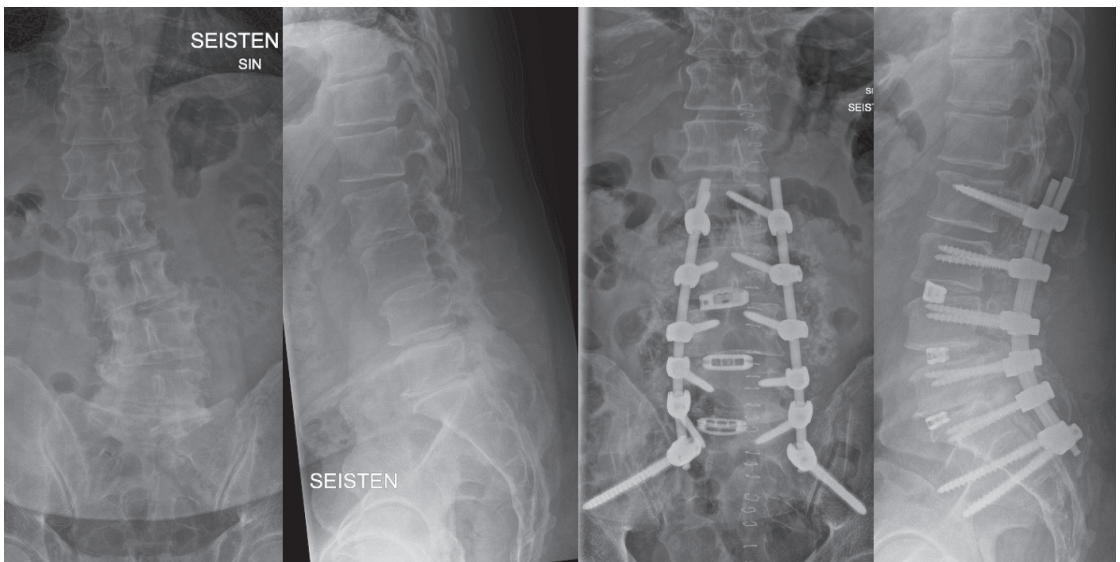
Radiographs demonstrating lumbar kypho-scoliosis accompanied with stenosis treated with lumbopelvic fusion.
